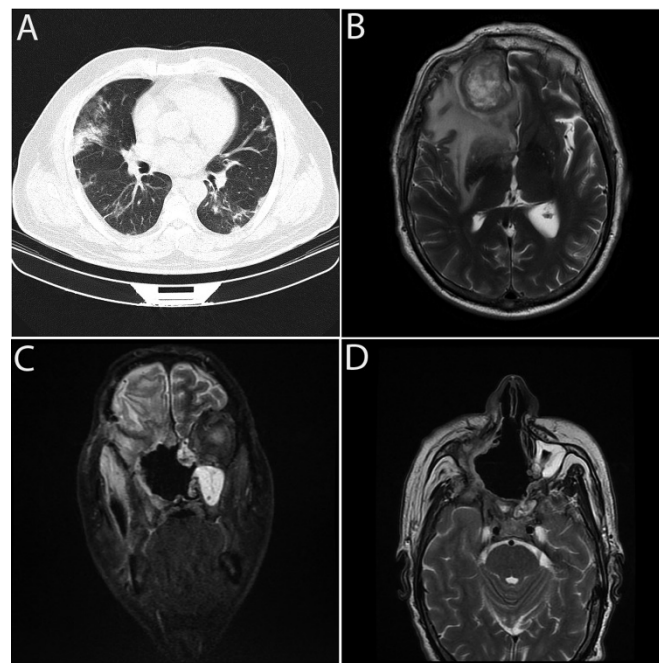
Chest CT Scan (parenchymal window) showing bilateral patchy ground-glass opacities and consolidation changes in both lungs, suggesting COVID-19 along with pneumonia
